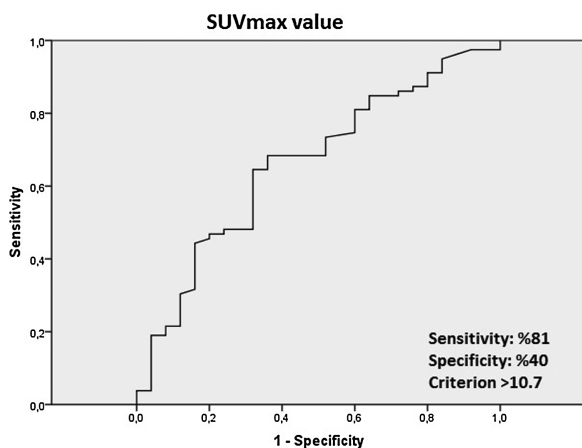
ROC analysis curve showing the SUVmax cut-off value of the patients.
